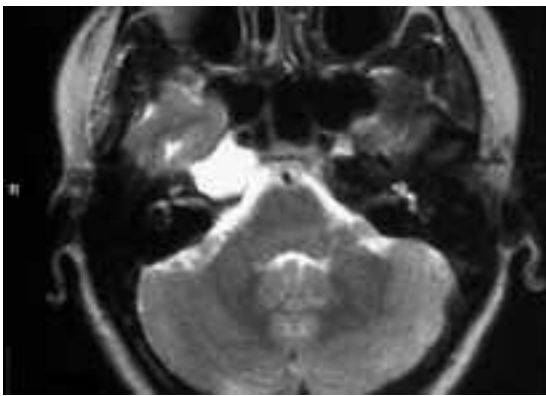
Axial MRI: on T2-weighted images, mass is hyperintense to brain parenchyma.
